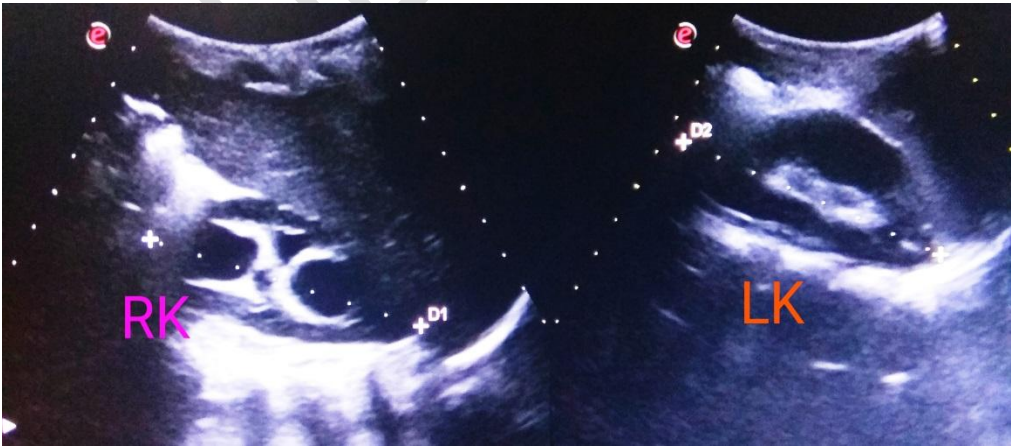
Ultrasound image showing mild hydronephrosis in right kidney compared to normal left kidney.
